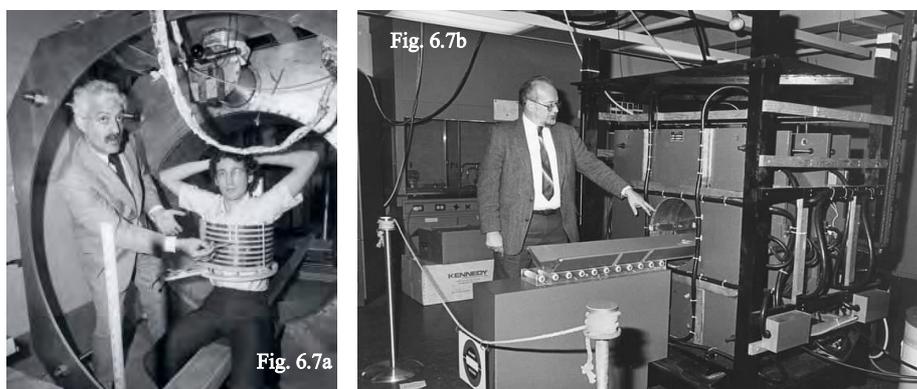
On 3rd July 1977, first MRI test on a live human patient was performed. MRI, identifies atoms by how they behave in a magnetic field, and is an extremely useful non-invasive method for imagining internal bodily structure and diagnosing diseases. MR imaging was invented by Paul C. Lautenberg who developed a mechanism to encode spatial information into an NMR signal using magnetic field gradients in Sept. 1971; and published the theory in March 1973.
